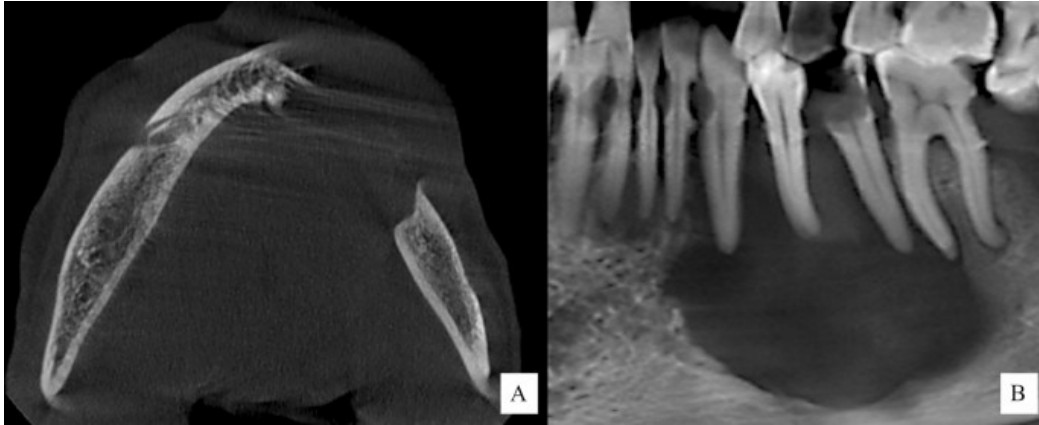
Case 1: (A) Axial and (B) panoramic reconstruction from the CBCT data set. CBCT imaging showing an osteolytic lesion with well demarcated borders. The lesion showed focal areas of loss of demarcation with associated destruction of buccal and lingual cortices.
